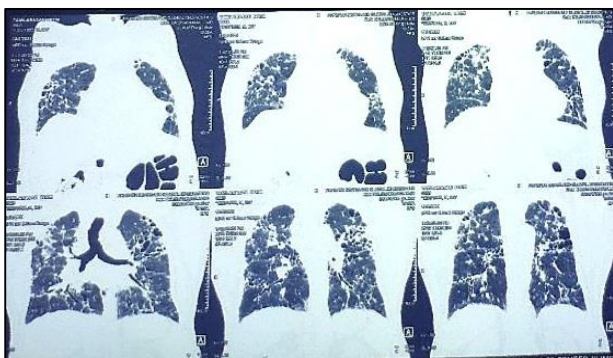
Coronal view of HRCT-bilateral apical thickening and traction bronchiectasis and PPFE.
